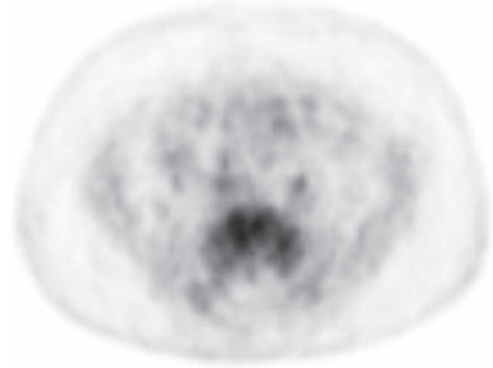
A 25-year-old man presented with back pain. Computed tomography of the abdomen demonstrated a right-sided renal tumor (a) with a large destructive lesion in the sacrum (b, c). CT did not demonstrate any other metastatic disease. A FDG-PET scan was performed (c) prior to palliative sacral surgery for intractable bone pain. FDG-PET did not demonstrate activity in the primary tumor but uptake was demonstrated in the metastatic sacral deposit (see also color plate section).
